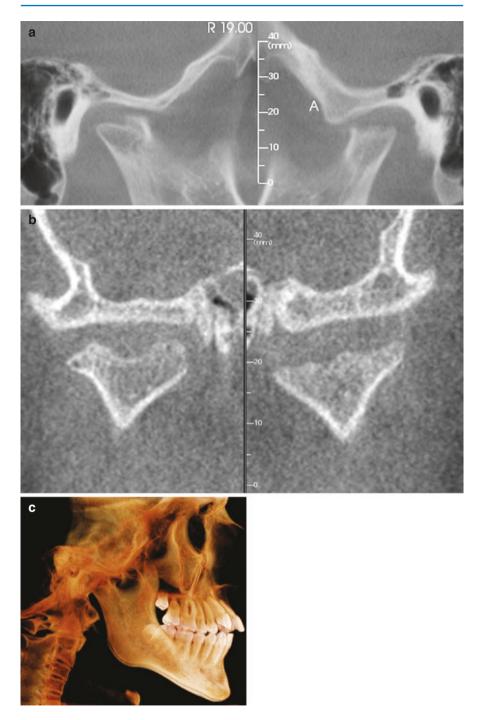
CBCT images of a 15-year-old male with juvenile idiopathic arthritis (JIA) show pronounced destruction of the articular surfaces (a and b), fusion of the posterior elements of the spine, and coronoid process elongation (c) (Courtesy, D. Hatcher, DDS)
